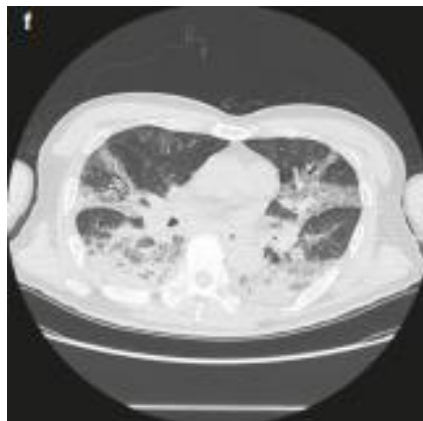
CT scan on day 3 post thermal injury.
